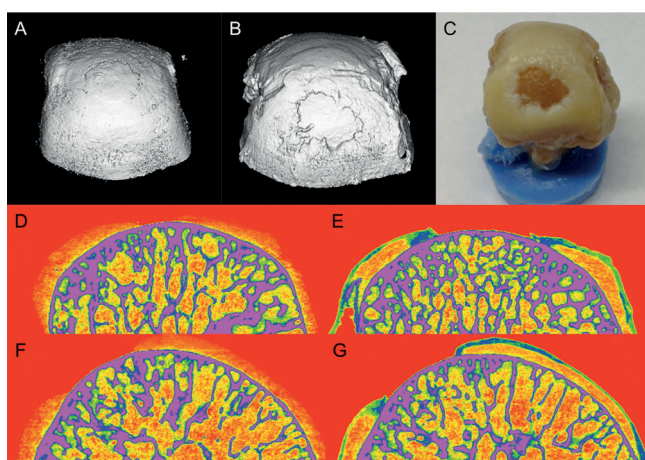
Cartilage defect in the proximal metacarpophalangeal (MCP) joint of a human index finger is clearly visualized only in the presence of NPs 2. The MCP was imaged before (A,D,F) and after (B,E,G) immersion in 40 mg NP/mL of NPs 2 for 24 h. The 3D CT reconstruction (B) shows the defect and is similar to that seen with gross inspection (C). Coronal (D and E) and sagittal (F and G) cross-section 2D-CT reconstructions are also shown, which further document the requirement of using NPs 2 to visualize the cartilage and the defect in the MCP.
